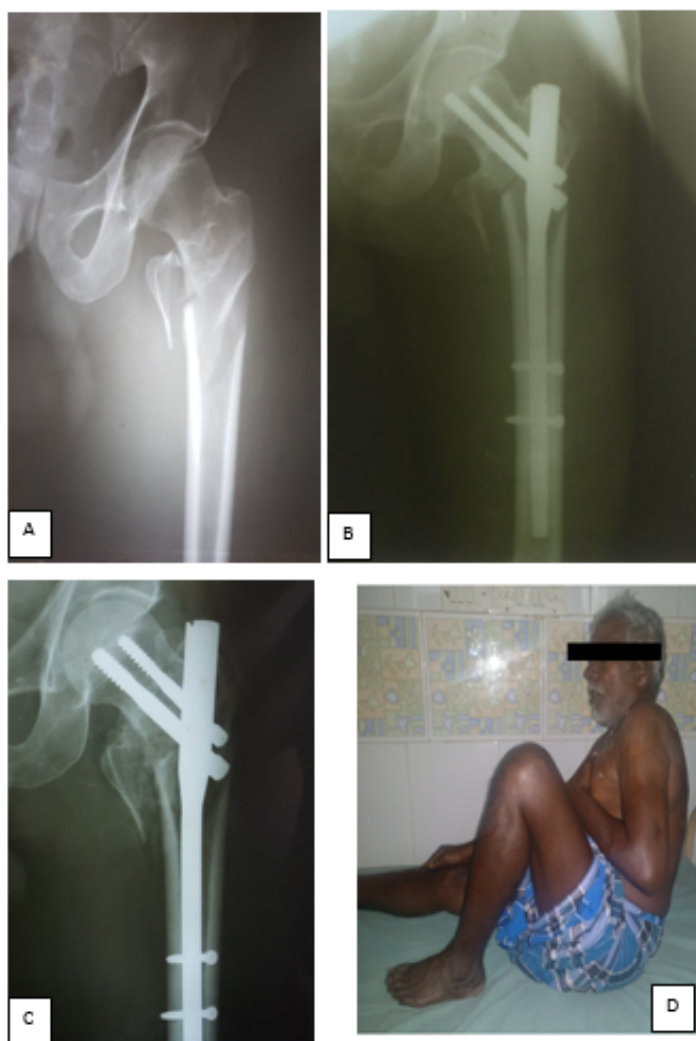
A: Pre-operative X-ray; B: Immediate Post-operative X-ray; C: X-ray taken at 2 months post-operatively; D: Functional outcome at end of 2 month
